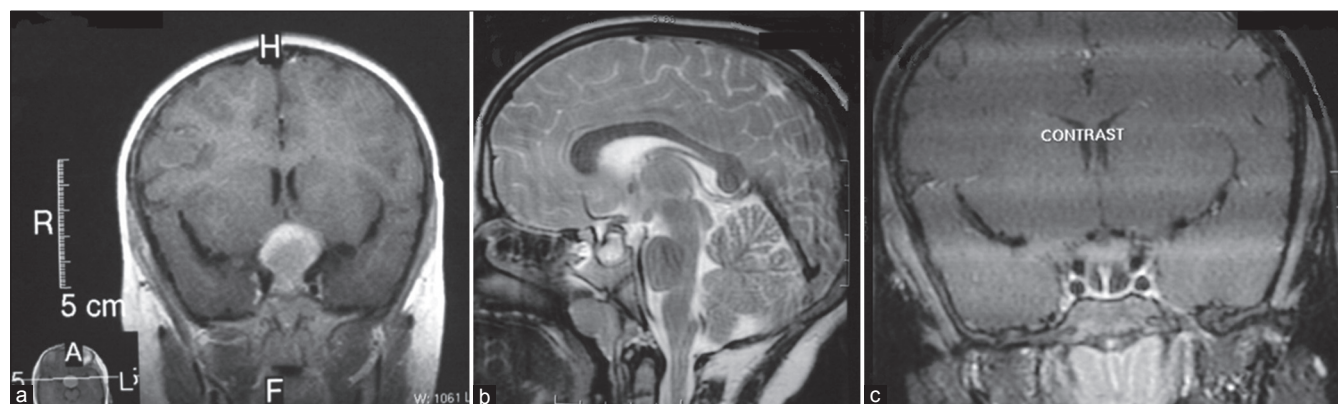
(a) Coronal section of MRI brain showing pituitary macroadenoma with predominant suprasellar component (February 2009), (b) MRI brain showing significant reduction in macroadenoma size after 10 months of cabergoline therapy (November 2009) (c) MRI brain coronal section showing empty sella with stalk traced till the floor of sella after 3 years of cabergoline therapy (January 2012)
